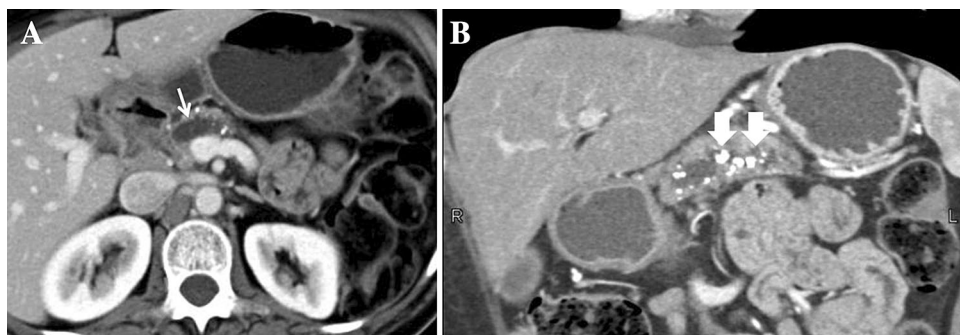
48-year-old woman with late-stage chronic pancreatitis. Contrast-enhanced venous phase CT shows a dilated main pancreatic duct (A thin arrow) and multiple intraductal calculi (B thick arrows).
